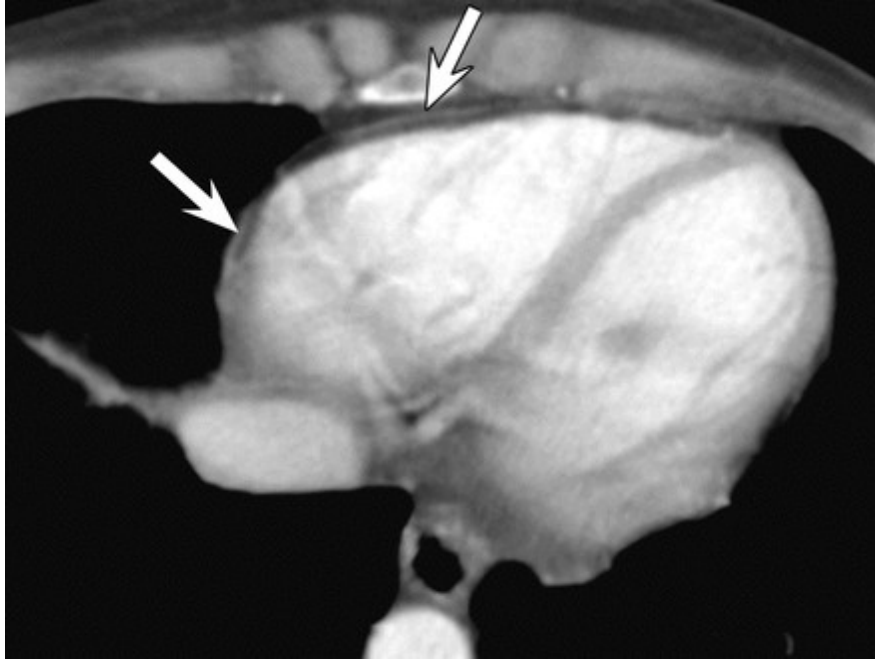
Normal pericardium. Axial contrast-enhanced CT scan
